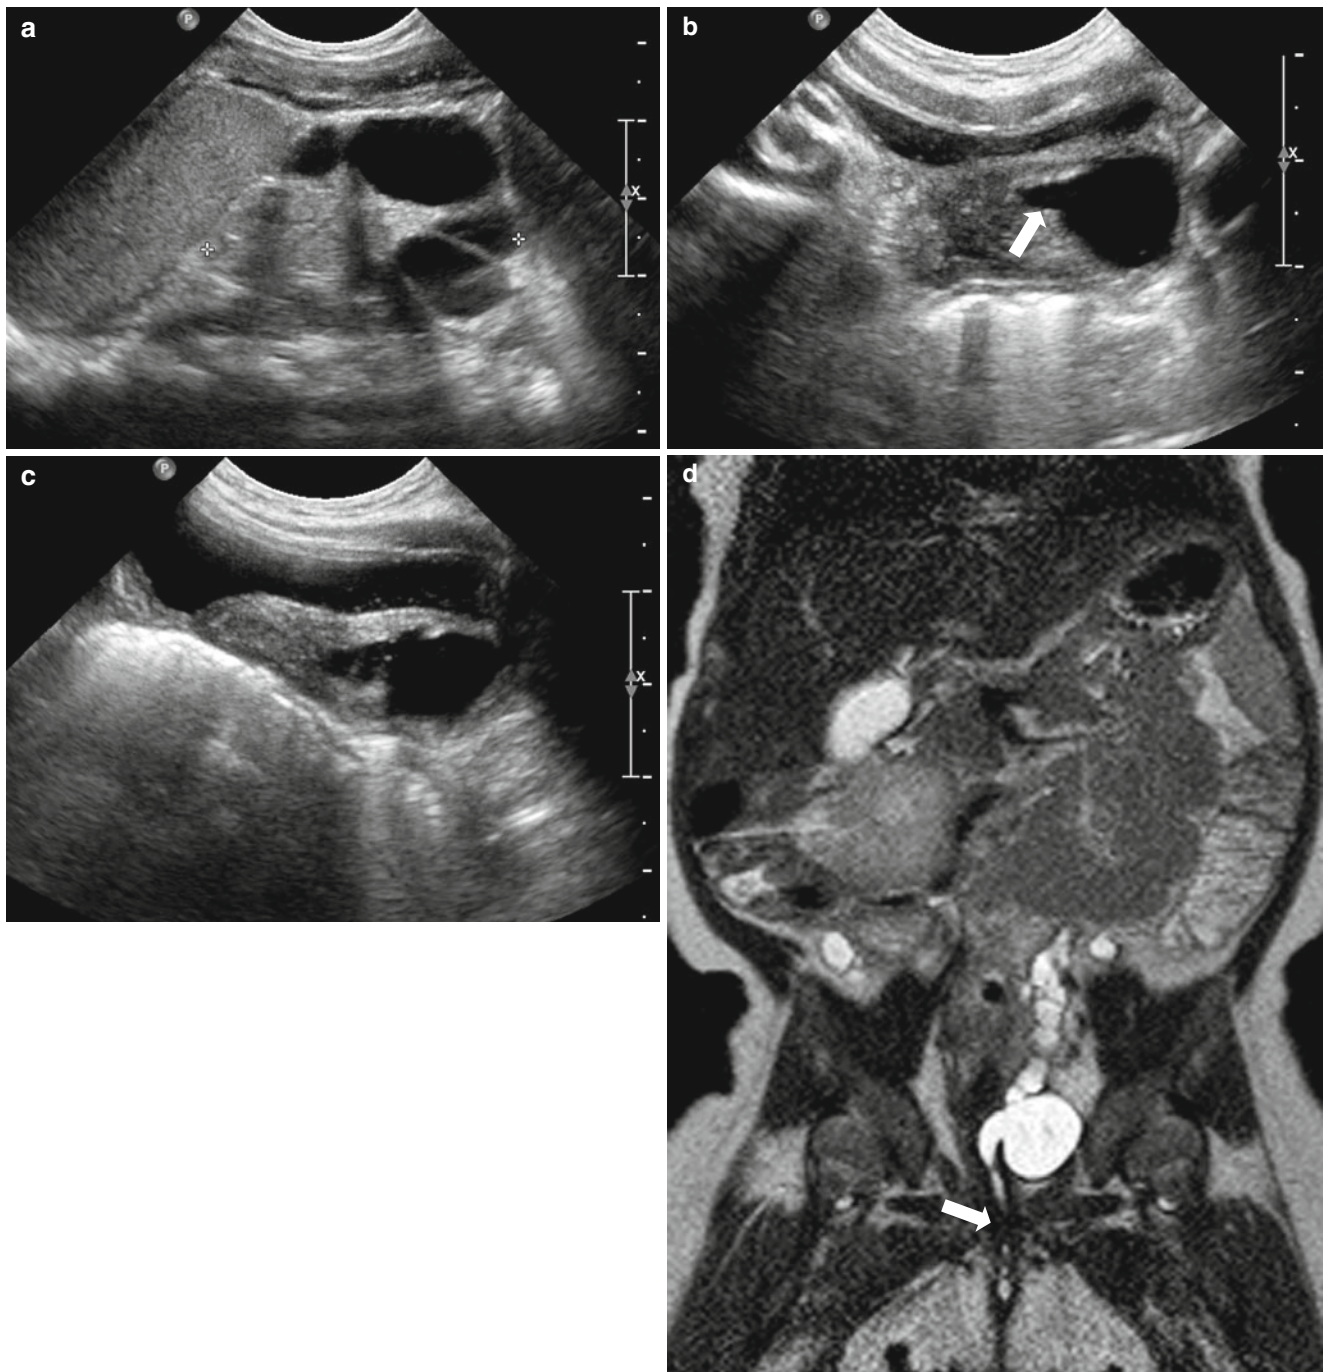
Ectopic ureter insertion to urethra in a 2-month-old girl. (a) Longitudinal US image of left upper abdomen shows multicystic dysplastic kidney. (b) Transverse US image of urinary bladder shows dilated left distal ureter with suspicious insertion to the lower midline (arrow). (c) Longitudinal US image of urinary bladder also shows lower insertion of the left distal ureter. (d) T2-weighted coronal MR
